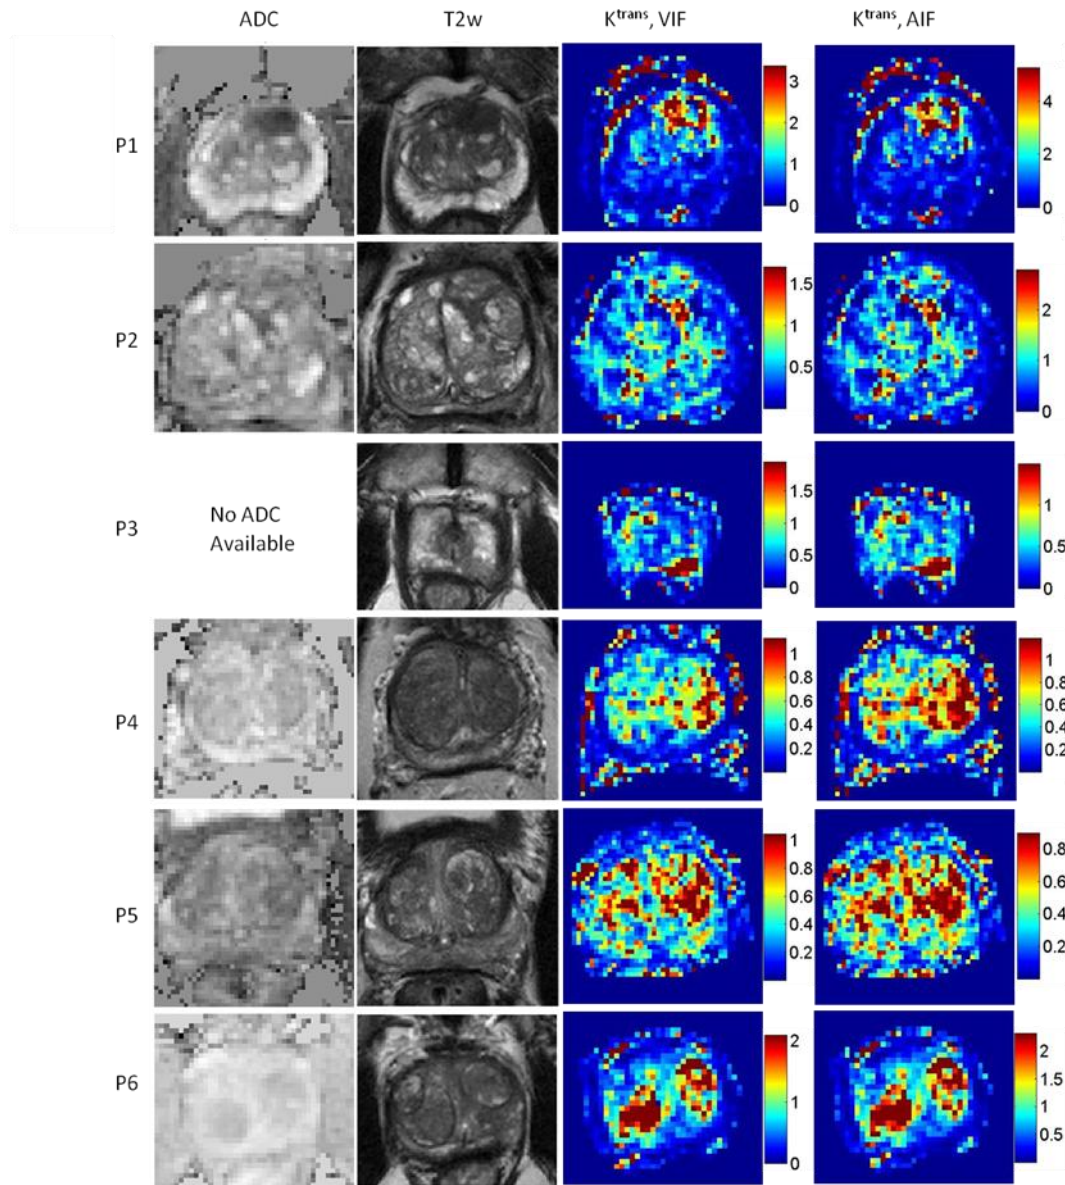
This figure shows the ADC map (first column), and T_2 -weighted MR image of the slices that were shown in Figure 5-5 which were used for tumor detection. The corresponding K^{trans} maps calculated for Tofts-Kety model using the normalized VIF (third column) and normalized AIF (fourth column) are also shown.
